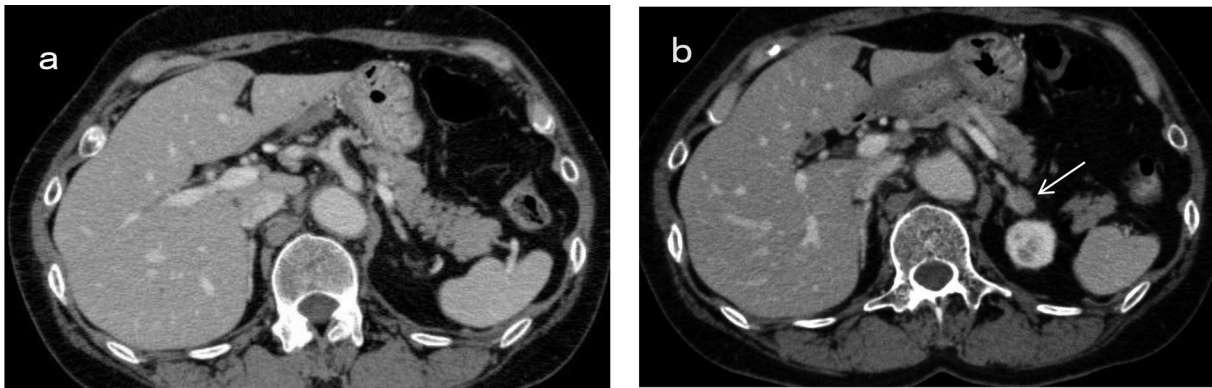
Abdominal computed tomography findings. a. No tumor is visible in the pancreas. b. A nodule is visible in the left adrenal gland (arrow).
